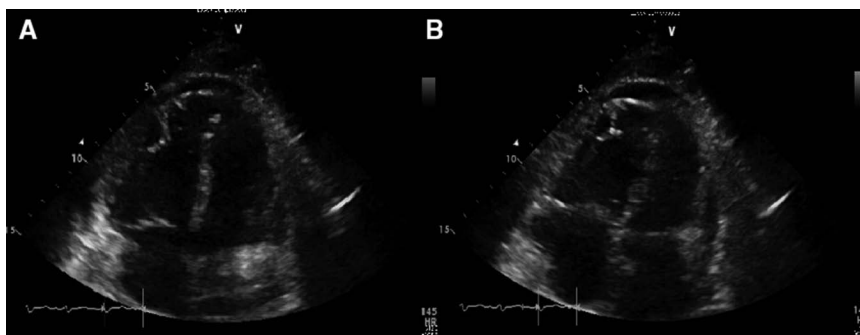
Transthoracic echocardiogram images obtained during diastole (A) and systole (B) demonstrating right ventricular dysfunction with hypokinesis of the mid right ventricular free wall and preservation of the apex.
